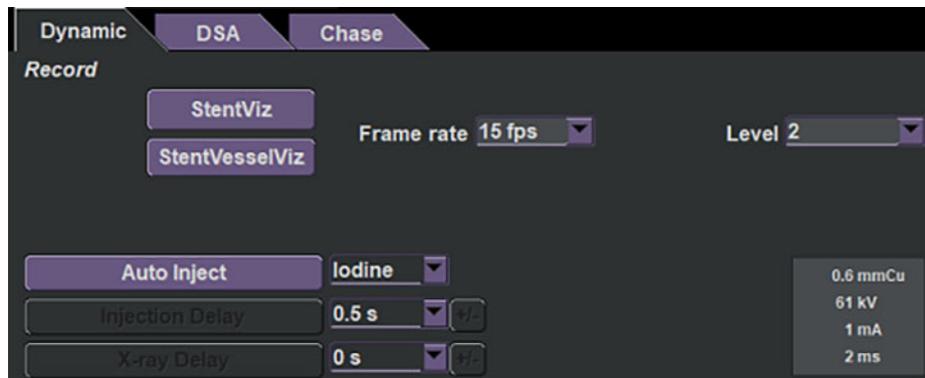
Touch Panel - X-Ray settings page
